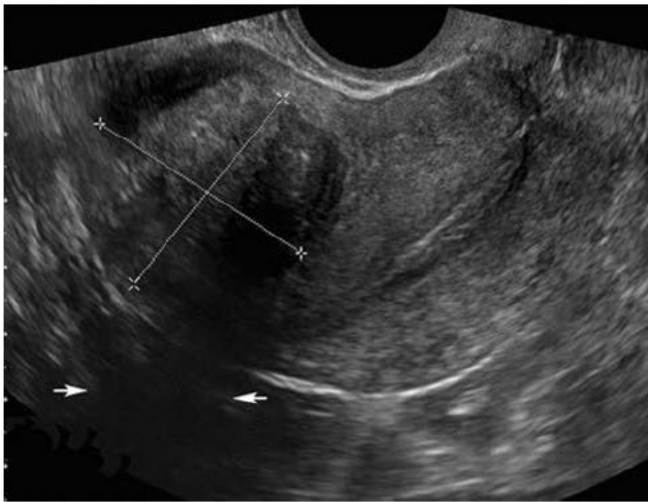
Transvaginal sonogram shows a leiomyoma marked by calipers and demonstrates *posterior acoustic shadowing* (arrows).
